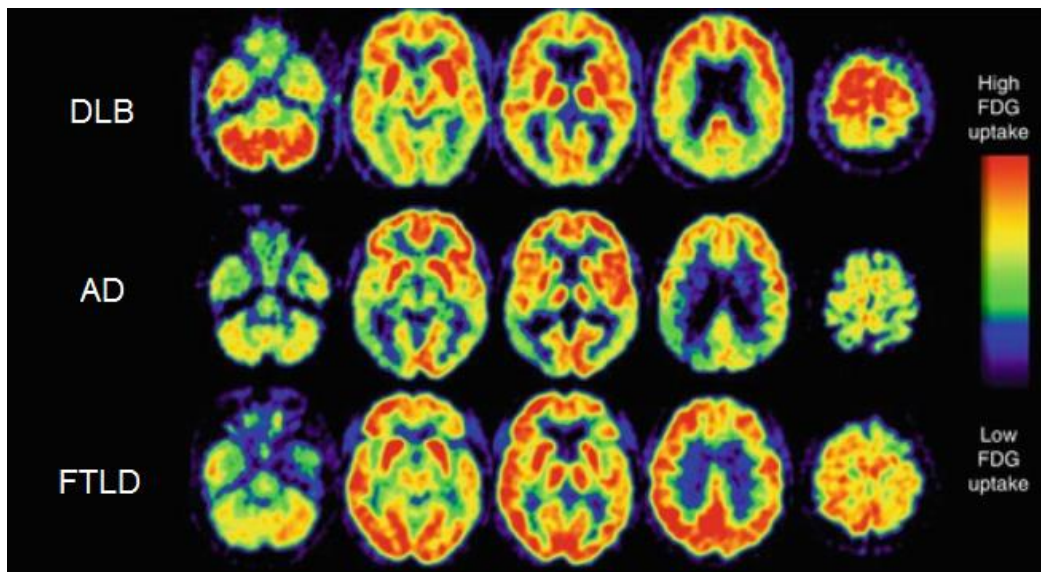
Common hypometabolic patterns in neurodegenerative dementias using FDG-PET. Adapted with permission from (Heinen et al., 2013).
